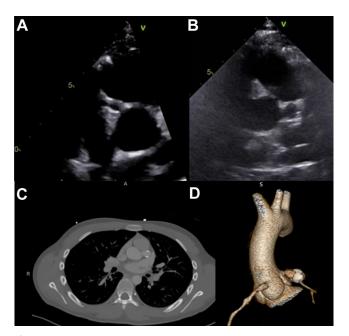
Imaging of coronary aneurysms. A: Right coronary artery with multiple fusiform aneurysms. B: Left coronary artery with large peripherally calcified (echo bright) aneurysm. C: Computed tomography (CT) angiogram of the coronary artery showing the left coronary artery with a large aneurysm with peripheral calcifications. D: Three-dimensional CT reconstruction of the coronary arteries showing the smaller right-sided aneurysms and the larger, calcified, left coronary artery aneurysm.
